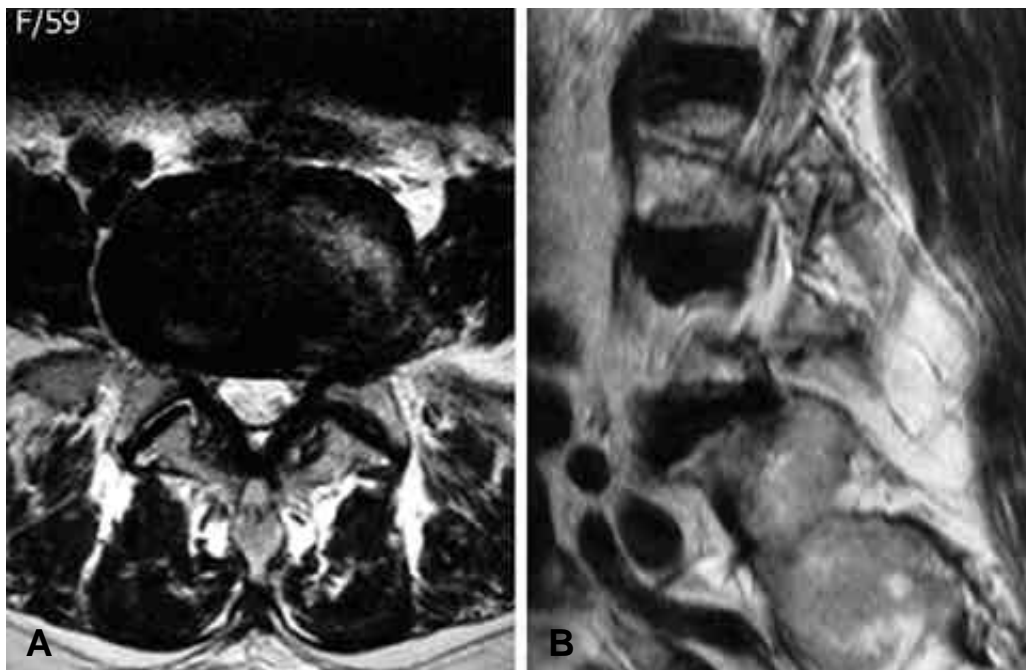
MR images of foraminal disc herniation. These three cases could be confirmed using sagittal images alone.
